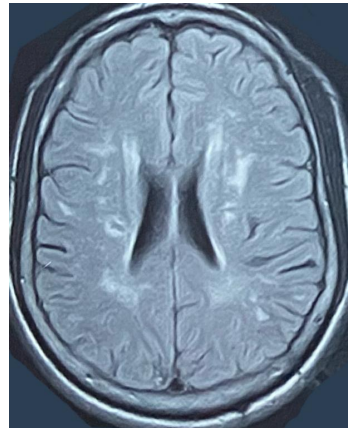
MRI encephal on in axial section and in FLAIR sequence showing periventricular and capsular hypersignals of the two hemispheres.
